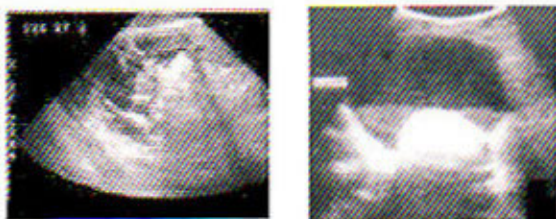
Ultrasonogram Findings- Complex Mass of polymorphic appearance and Dermoid Plug.
